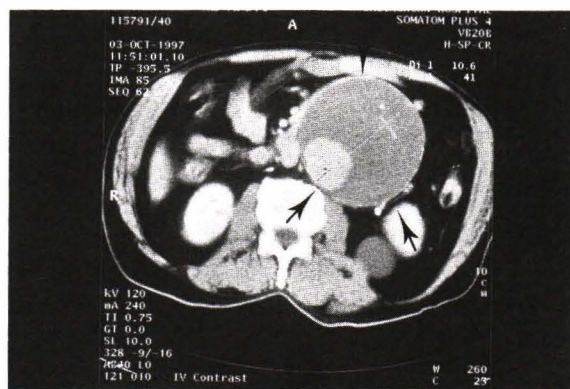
Computed tomography of the abdomen showing a large abdominal aortic aneurysm (arrows).
